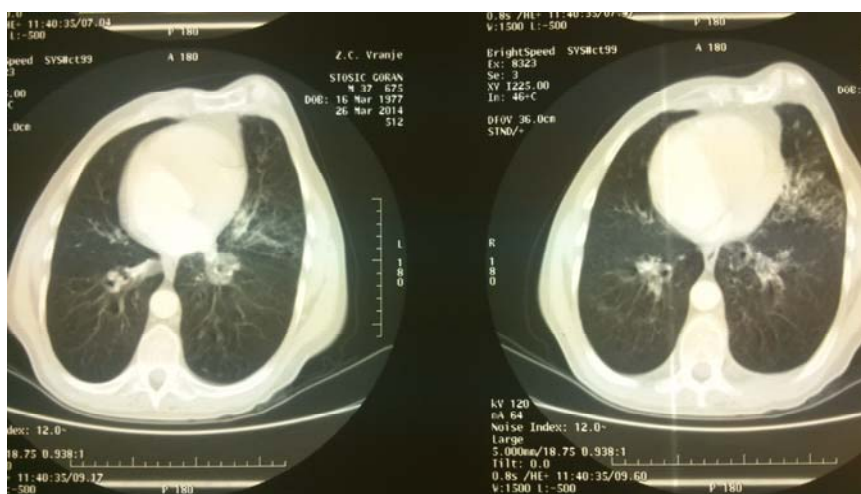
Contrast-enhanced computed tomography images show dextrocardia and bronchiectasis in the lower lobes, dominantly on the left side.
